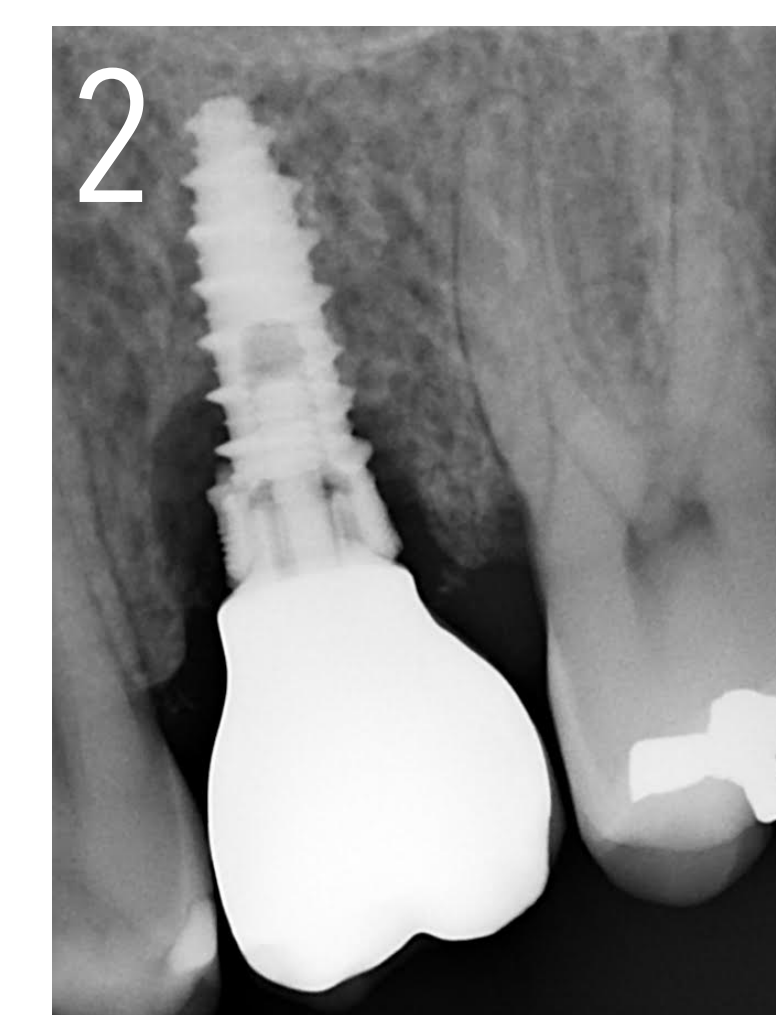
Initial X-ray | Regular implant, internal connection, screw-retained crown | Vertical bone defect
